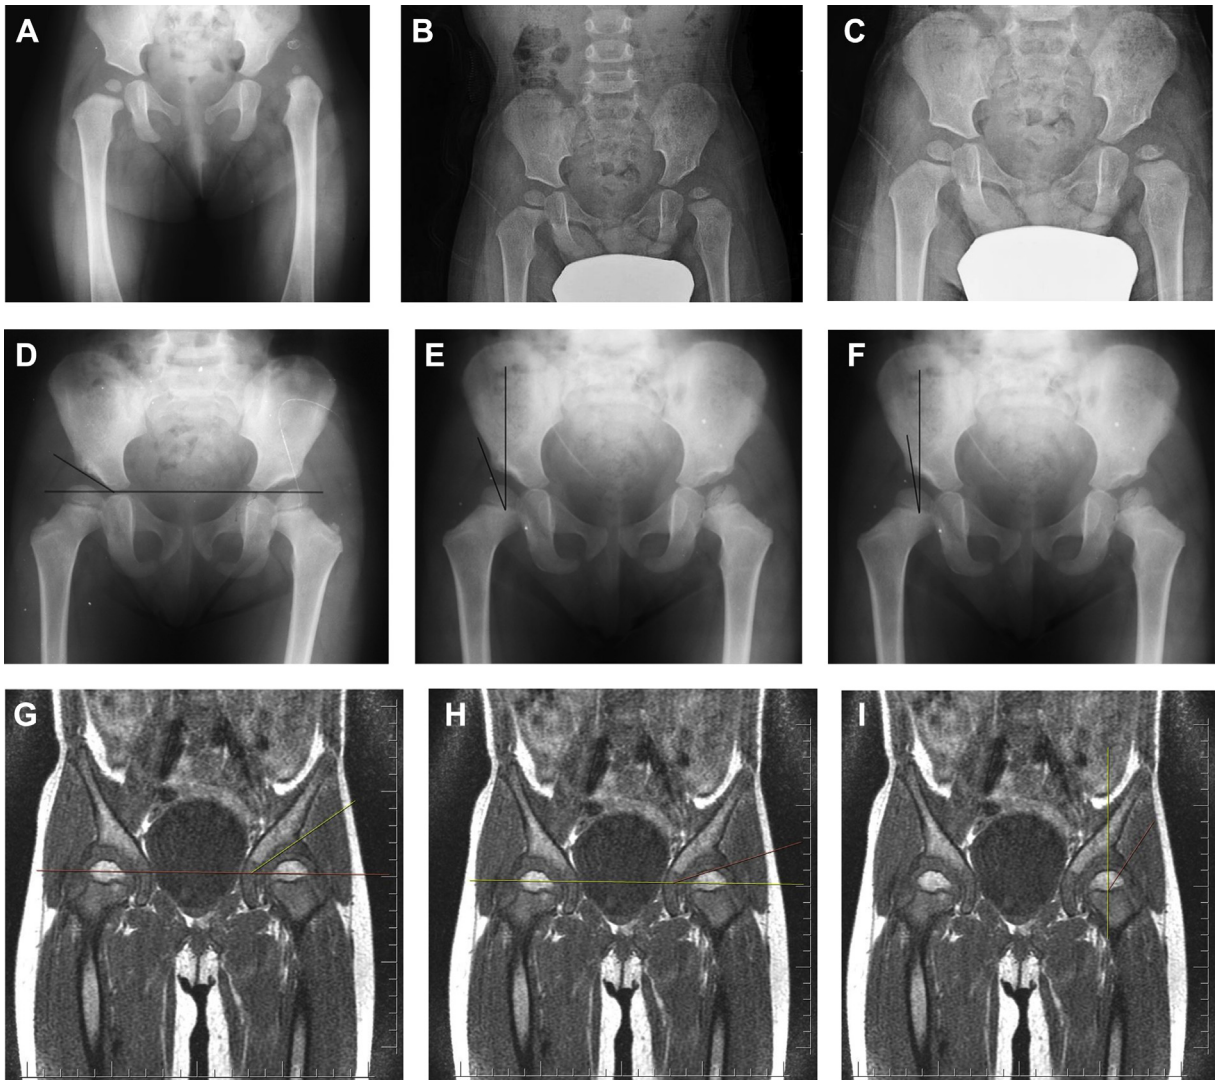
(A) Preoperative X-ray: Patient was operated at 8 months of age. The patient has IHDI Grade 4 dislocation on the left hip. (B) Control during the 3rd postoperative year. RAD was observed (C) Control during the 5th postoperative year. (D) Last control X ray at 7th postoperative year. Acetabular index was measured in x-ray. (E) Last control X ray at 7th postoperative year. Center edge angle of Wiberg was measured in x-ray. (F) Last control X ray at 7th postoperative year. Center edge angle of Ogata was measured in x-ray. (G) Last control at 7th postoperative year. Osseous acetabular index was measured in MRI. (H) Last control at 7th postoperative year. Cartilaginous acetabular index was measured in MRI (I) Last control at 7th postoperative year. Cartilaginous center edge angle was measured in MRI.
